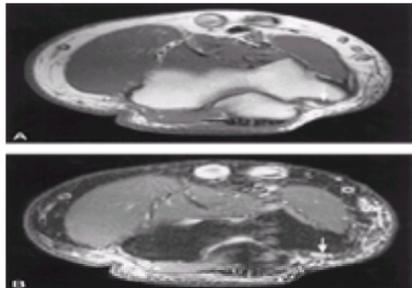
Ulnar entrapment. Axial T1 (A) and short tau inversion recovery (STIR) (B) images of the right elbow taken at the level in which the ulnar nerve passes through the cubital tunnel. A: On this T1-weighted image, a normal sized right ulnar nerve is nicely demonstrated surrounded by perineural fat (arrow). B: The STIR image, however, demonstrates abnormally increased hyperintensity within the nerve that is abnormal (arrow) and that, in the presence of appropriate symptoms, is an indication of ulnar nerve entrapment.
